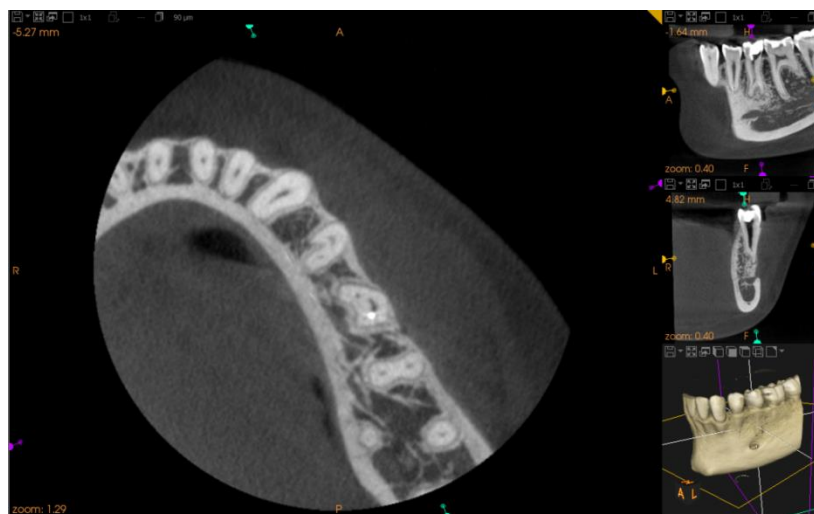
CBCT images demonstrate C-shaped root canals in the mandibular second premolar
